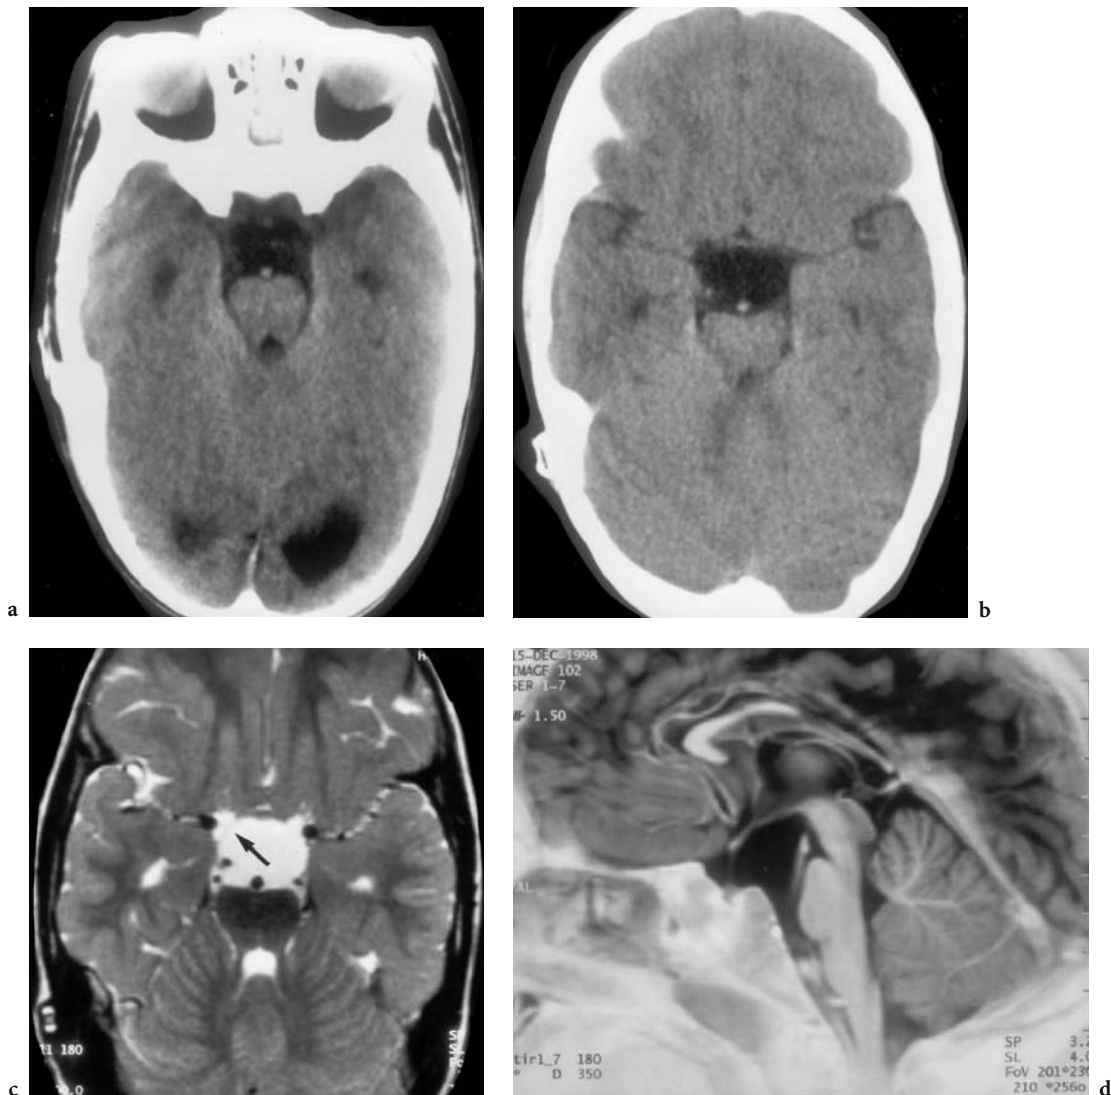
A 4-year-old boy with congenital (shunted) hydrocephalus, presenting with progressive visual deficits. Diagnosis: suprasellar arachnoid cyst. CT: a Axial CT taken 2 years before the current presentation, showing a wide suprasellar cistern. b Corresponding CT at the time of visual deficits where the suprasellar cistern appears expanded and the brainstem flattened. MRI: c Corresponding axial T2-weighted image demonstrating a miniscule wall (*small arrow*). d Midsagittal T1-weighted IR view with extension of the pituitary stalk/chiasm complex, elevation of the floor of the third ventricle, and pressure exertion by the basilar artery against the flattened, deformed pons. (With permission of MÜLLER-FORELL 2001)
